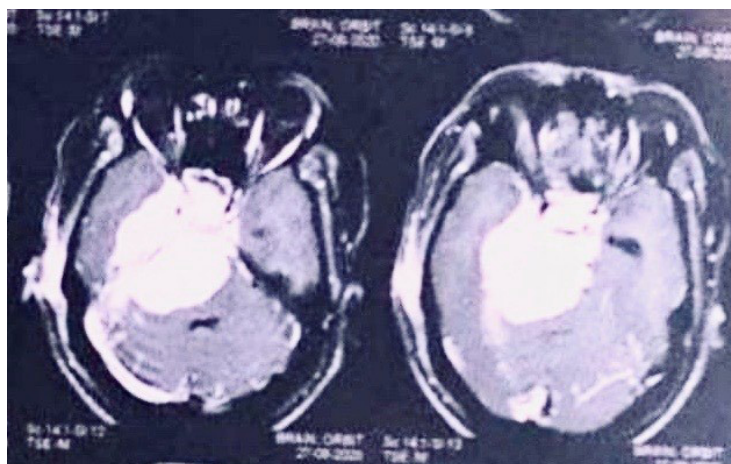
MRI scan showing a large skull meningioma
